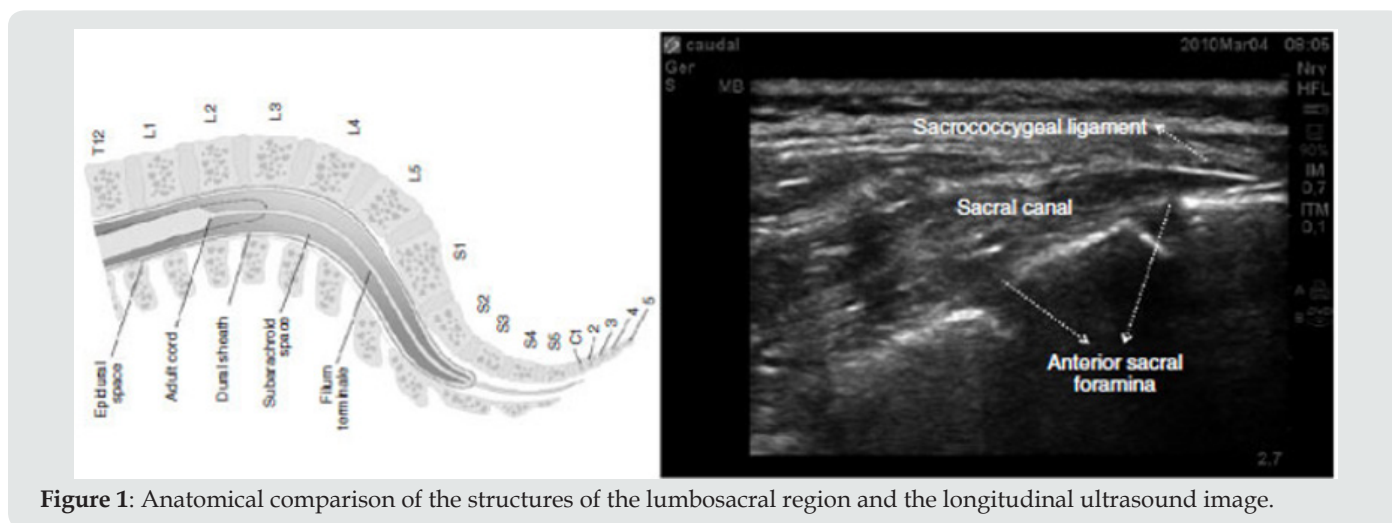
Anatomical comparison of the structures of the lumbosacral region and the longitudinal ultrasound image.
